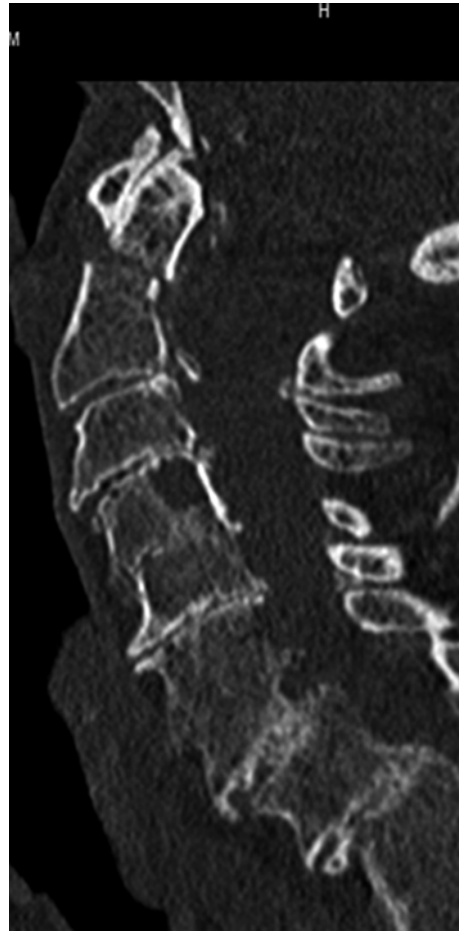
CT scan of an odontoid fracture (C2) in an elderly female with significant osteoarthritis changes from a fall from standing height hitting her forehead forcing her cervical spine in hyperextension. She was treated nonoperatively in a hard cervical collar and suffered no neurologic deficits
